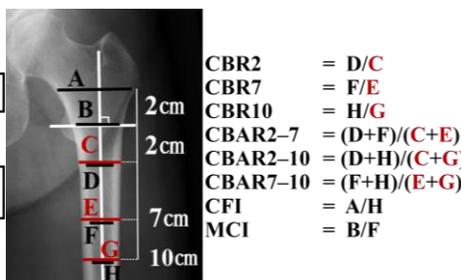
Parameters measured from an anteroposterior hip X-ray.
